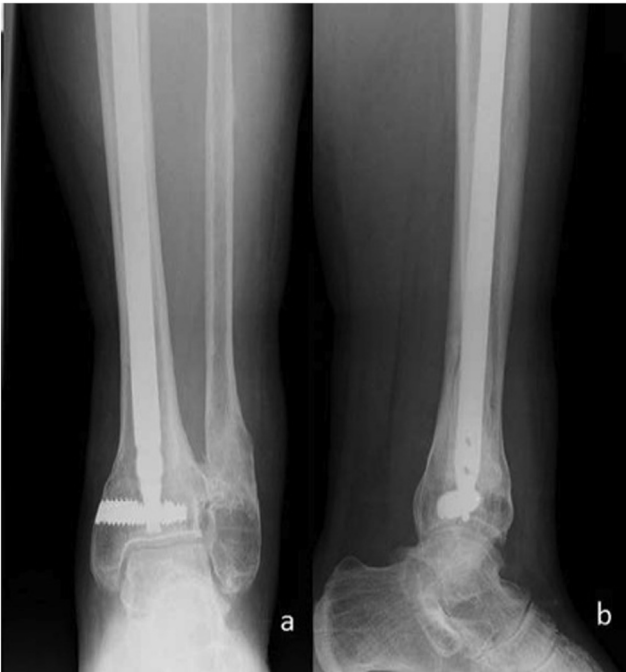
Final follow-up (postoperative 3 years) AP (a) and lateral (b) X-rays of Patient 1.
